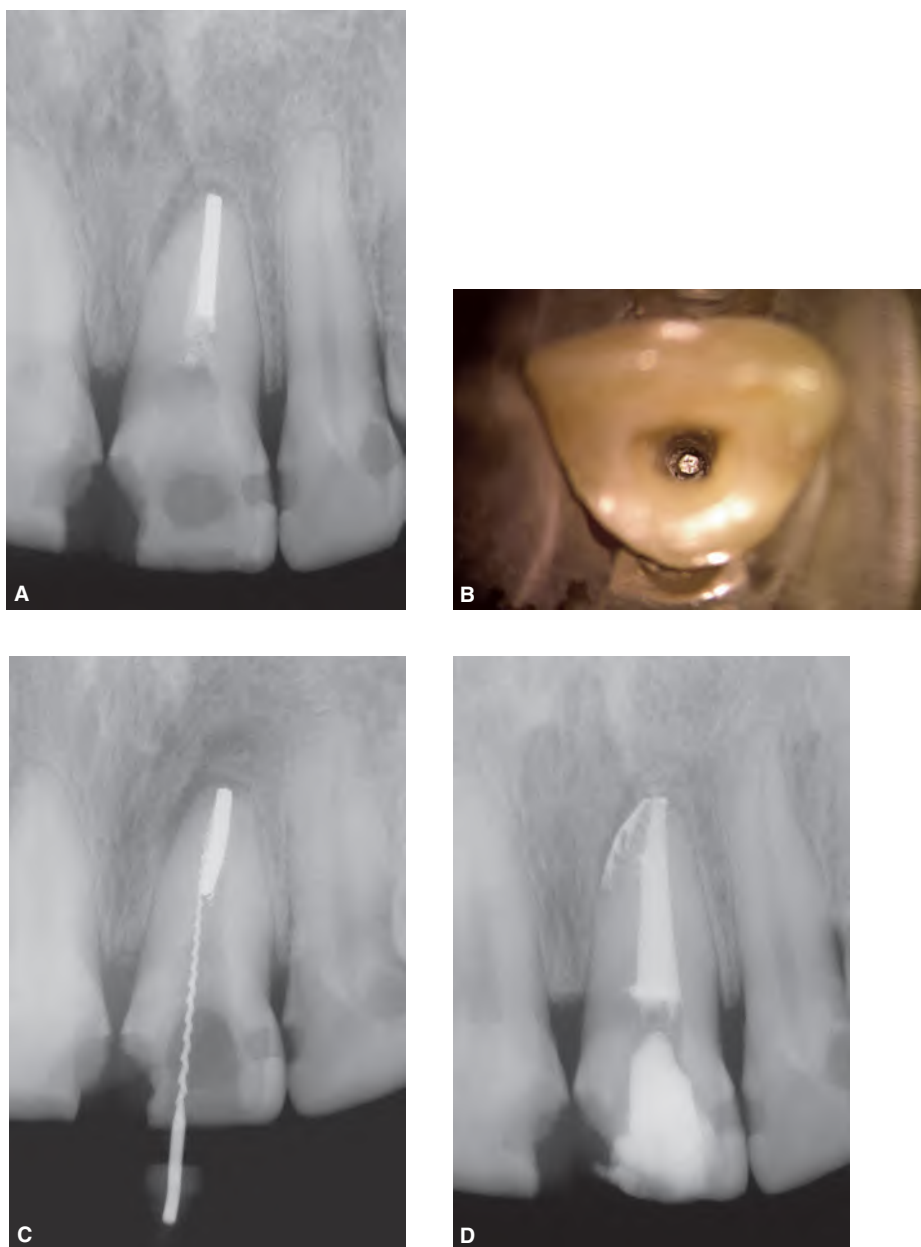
A. Preoperative radiograph of failing endodontic treatment in left central incisor. Note the sectioned silver point and asymmetrical lesion apically. B. Photograph showing the deeply positioned and exposed silver point. C. Working length radiograph showing a 35 Hedstrom file bypassing the silver point to length. D. A Postoperative radiograph showing obturation control, apical corkage and filling material in many lateral canals. (Courtesy of Dr. Michael J. Scianamblo, San Rafael, California, U.S.A.)
